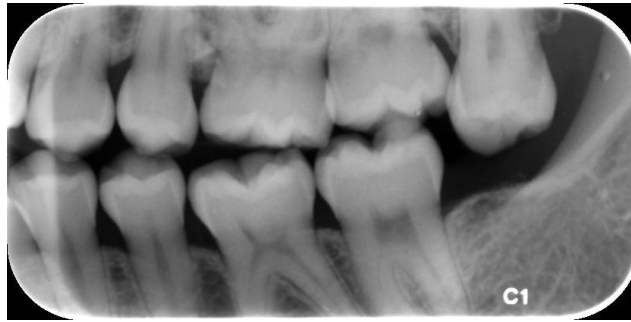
Digital bitewing radiograph with intact surface (R0).
